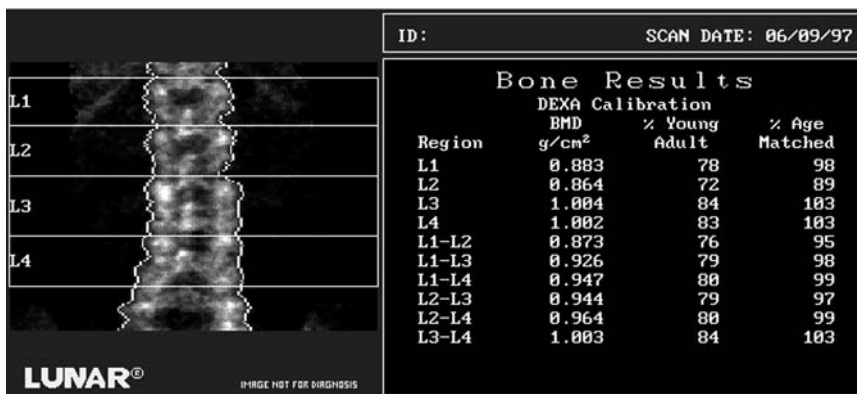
A DXA PA lumbar spine study acquired on the GE Lunar DPX. There is a marked increase in the BMD between L2 and L3, which is maintained at L4. The image faintly suggests sclerosis in the region of the facet joints at L3 and L4. This is more dramatically seen in the plain film of this patient shown in Fig. 2-18.
